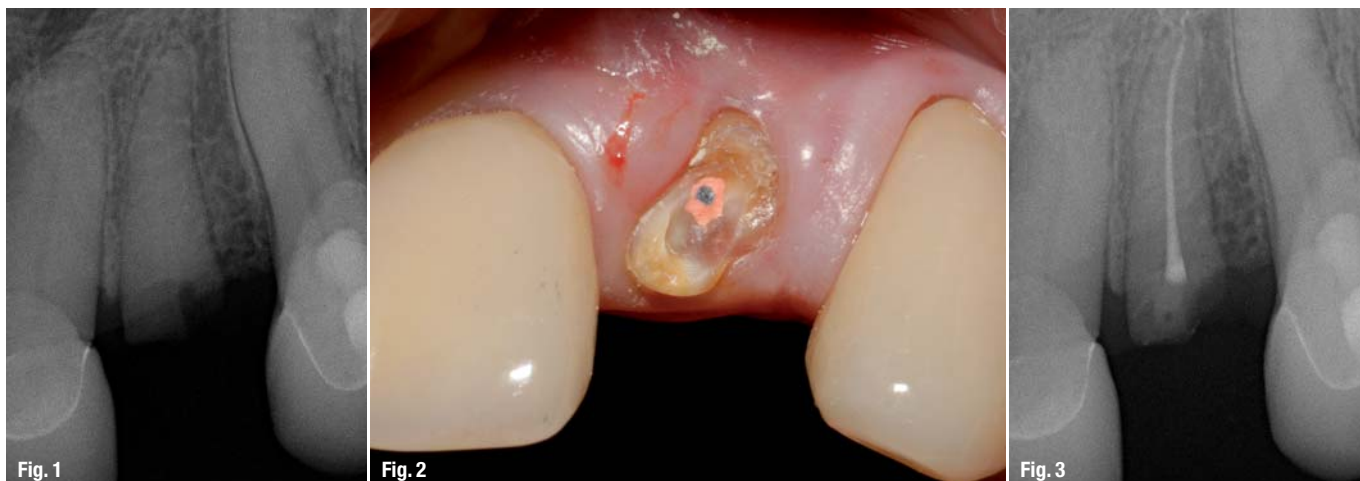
Single-tooth radiograph showing the fractured tooth #22.
